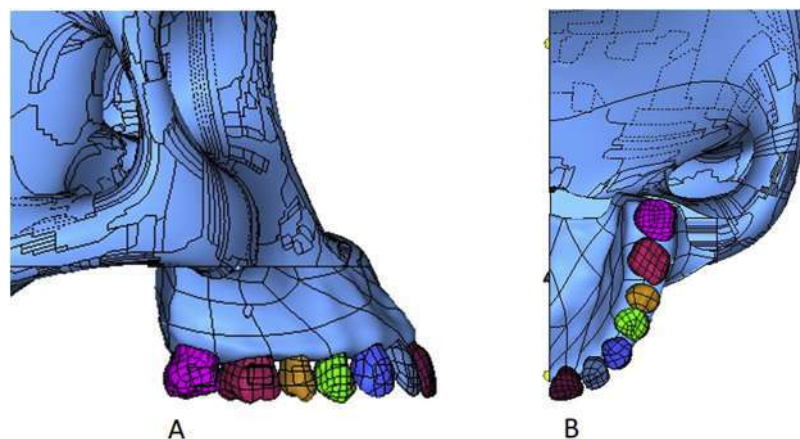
The process for the 3D FEA model: A, 3D reconstruction of the CT scans; B, 3D FEA model occlusal section.
